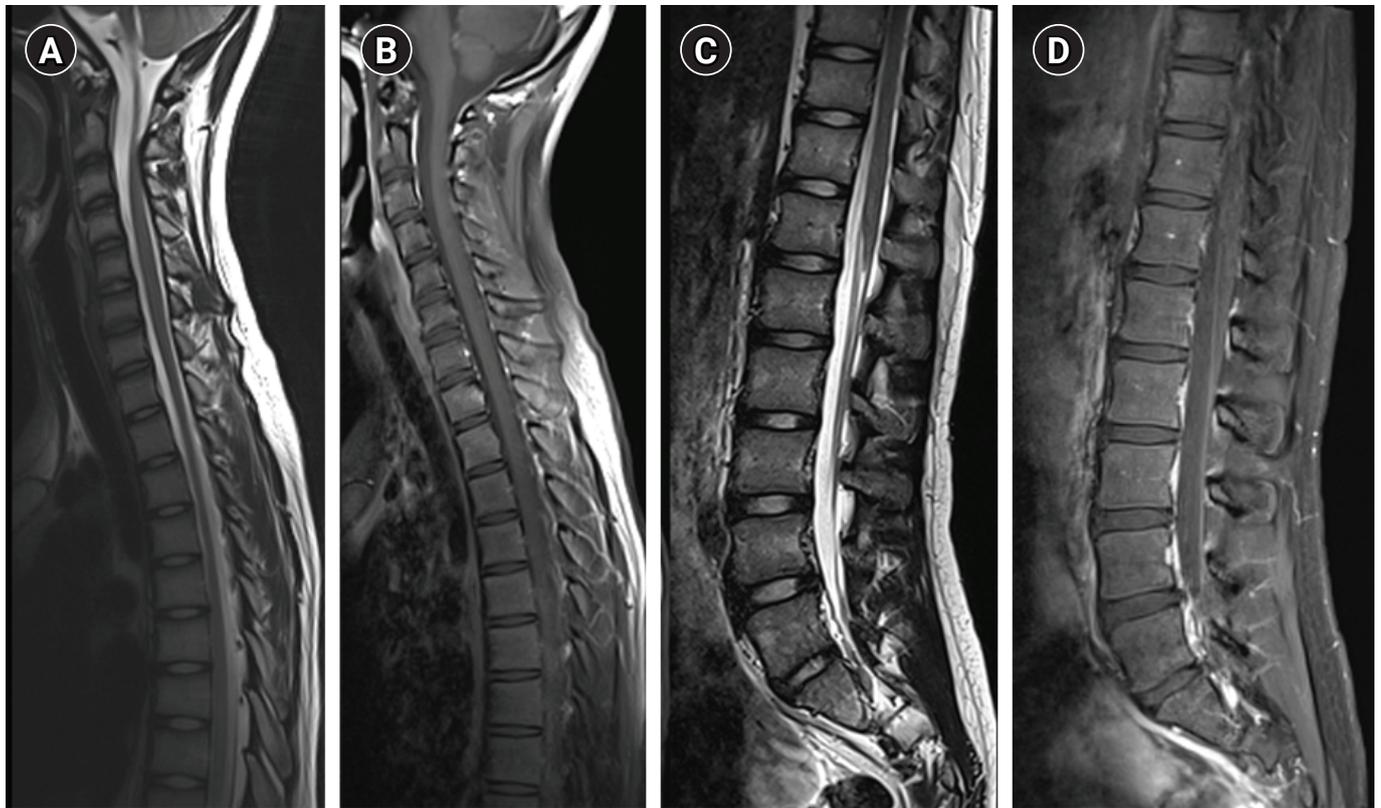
Magnetic resonance imaging of the spine. (A) A T2-weighted image and (B) a T1-weighted image with gadolinium enhancement in the upper spine. (C) A T2-weighted image and (D) a T1-weighted image with gadolinium enhancement in the lower spine.
